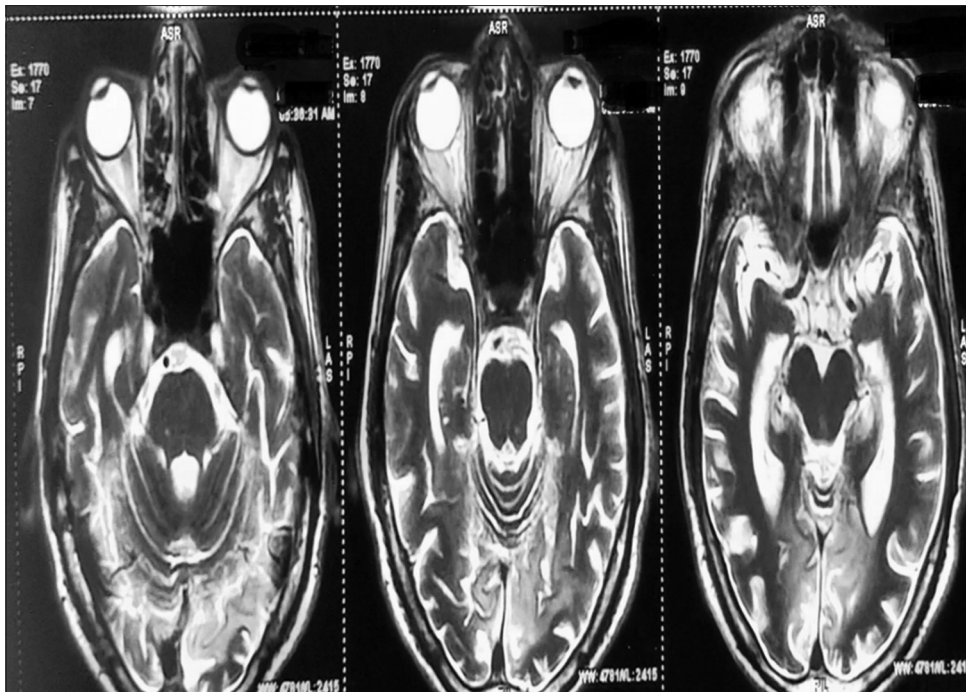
Magnetic resonance imaging brain shows T2 hyperintensities in bilateral occipital region
